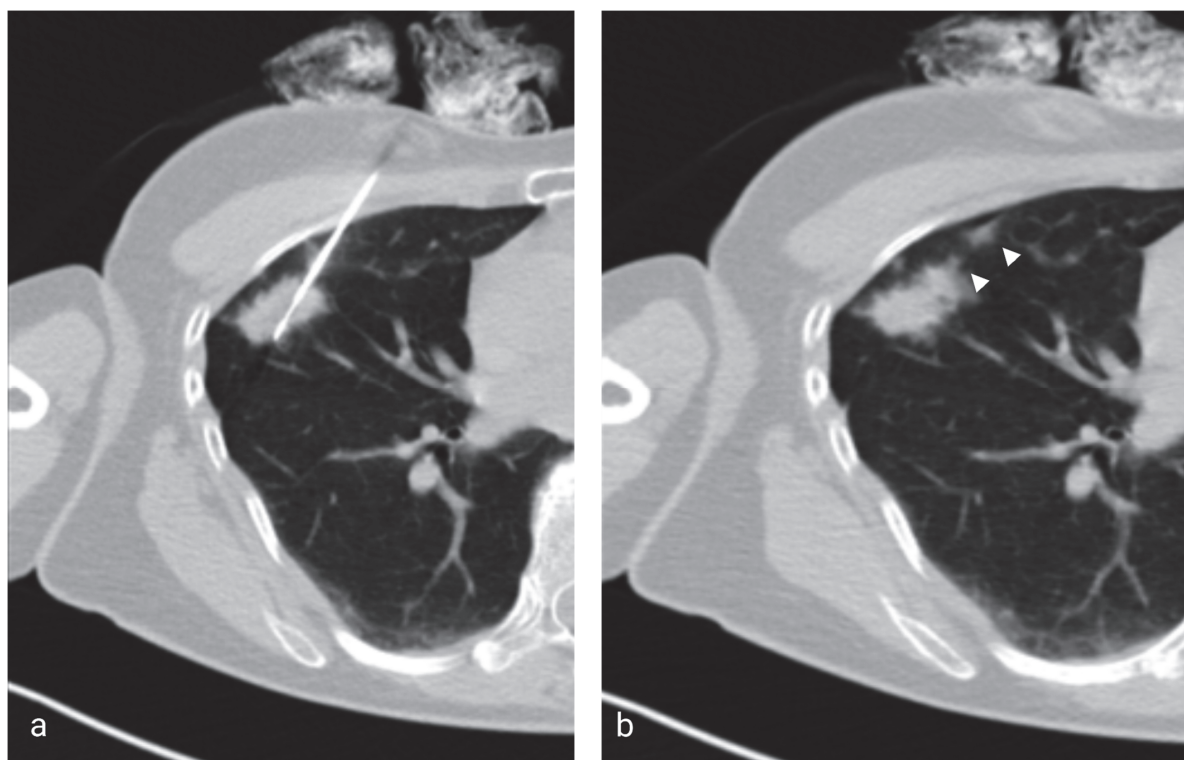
(a) Axial low-dose CT showing the 17G coaxial needle and the 18G biopsy needle within a right middle lobe mass. (b) Image taken immediately after the injection of saline solution and removal of the coaxial needle showing the hyperattenuating needle tract (arrowheads).
